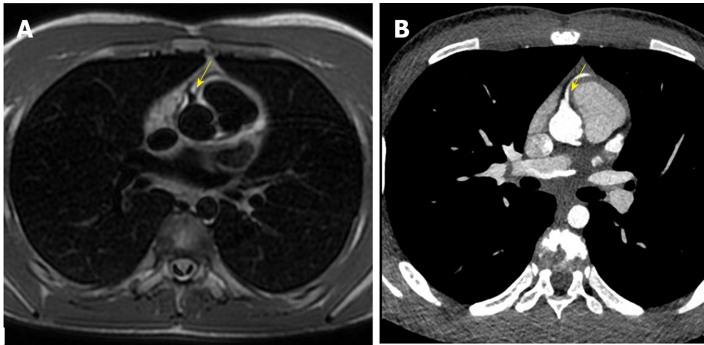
Origin of left anterior descending artery. A: Origin of left anterior descending artery from right coronary artery evaluated with 1.5 T cardiac magnetic resonance (yellow arrow); B: Origin of left anterior descending artery from right coronary artery evaluated with third generation dual source cardiac computed tomography (yellow arrow).
